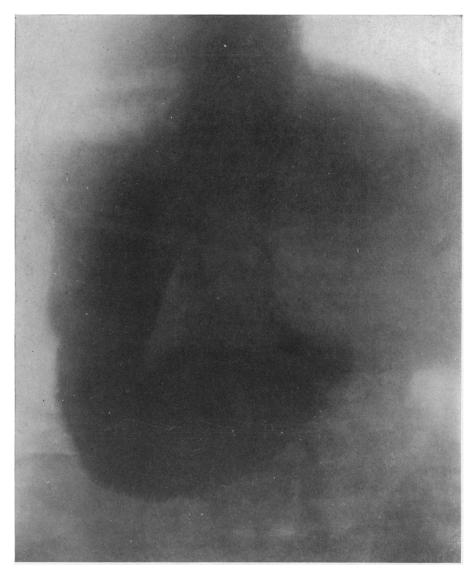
X-ray picture of Case I after operation. Only ptosis of the stomach is observed.
